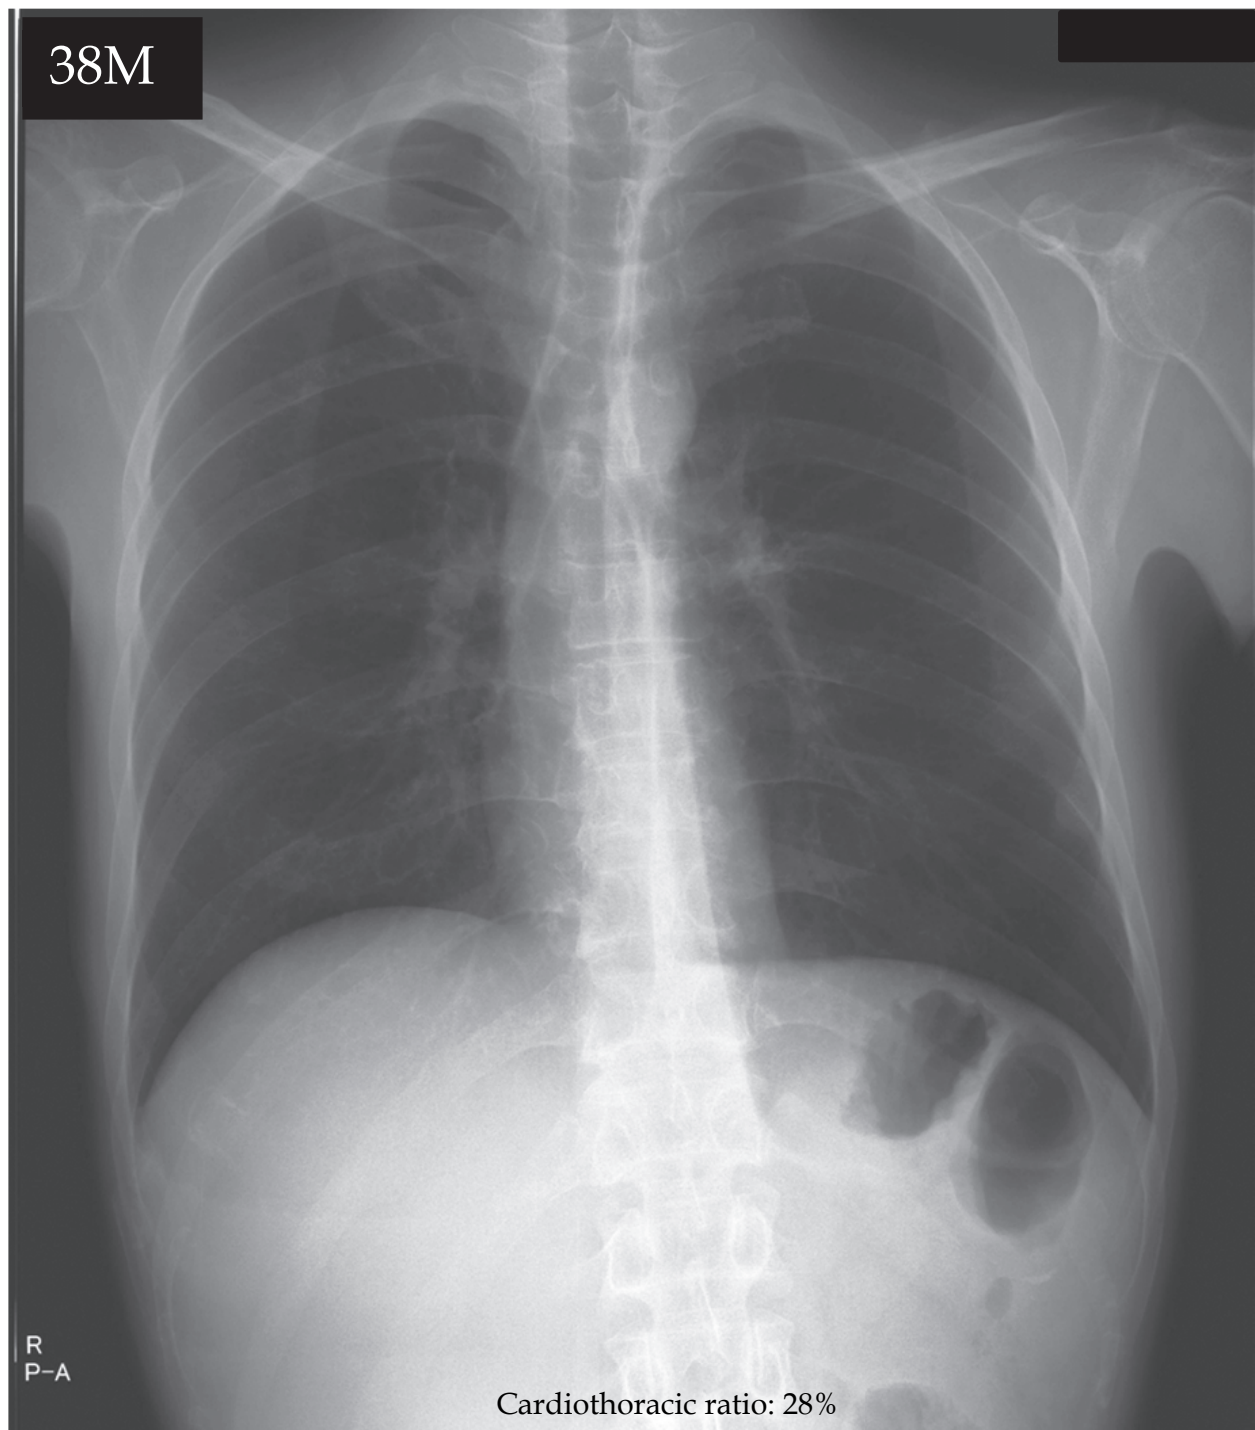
Chest roentgenogram of a 38-year-old male patient with small heart syndrome (cardiothoracic ratio: 28%) in which vertebral scoliosis was also noted. From about 15 years ago, the patient suffered from severe general malaise, easy fatigability, dyspnea on effort, palpitations and chest pain. He also occasionally developed severe dyspnea with hyperventilation, trembling, sweating and sleep disturbance. He found that upon obtaining employment, he could not work as expected. Upon consulting a psychiatrist 10 years ago, he was diagnosed with anxiety neurosis and treated with medication. He subsequently developed alcoholism. He frequently visited emergency outclinics due to severe dyspnea and anxiety.
